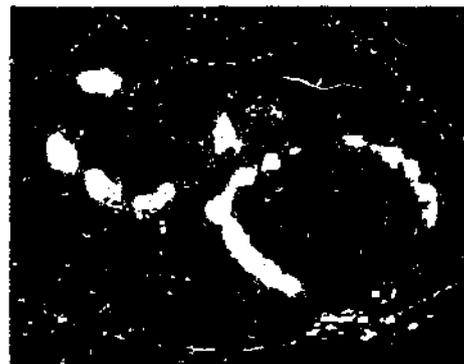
Doppler ultrasound of two corpora lutea in one ovary (signifying dual ovulation). The corpus luteum typically appears as an echo-filled cyst with a ring of peripheral vascularity. Colours reflect variations in blood flow, with yellow as the fastest.
